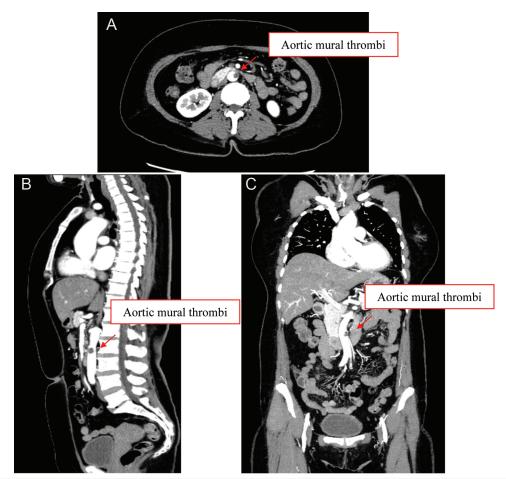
Computed tomography arteriography (CTA) demonstrated floating aortic mural thrombi at the infrarenal abdominal aorta in the (A) axial view, (B) coronal view, and (C) sagittal view.
